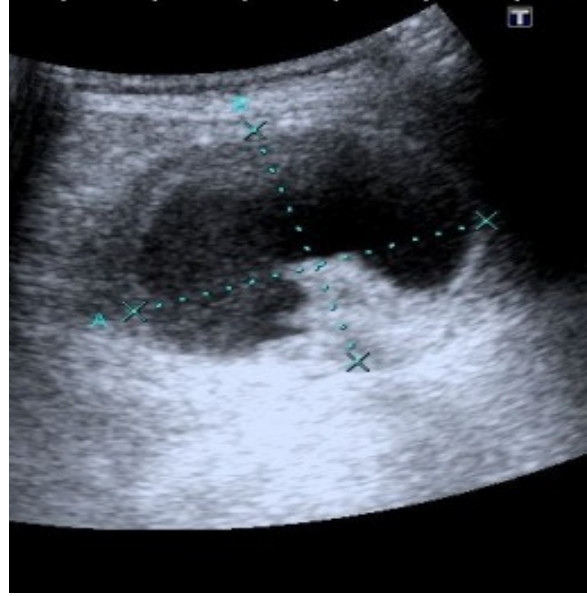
Initial Ultrasound of the right lumbar swelling, showed anechoic cystic mass with small intracystic echogenic fat component.
